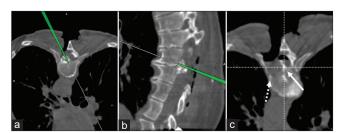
(a) Intraoperative T8–T9 axial computed tomography (CT) scan with navigation probe, (b) intraoperative left paramedian sagittal CT scan with navigation probe (green line), and (c) intraoperative T8–T9 axial CT scan showing the known small median calcific residual tightly attached to the dura (white arrow) and the complete removal of the recurrent herniated disc (white dotted arrow).
